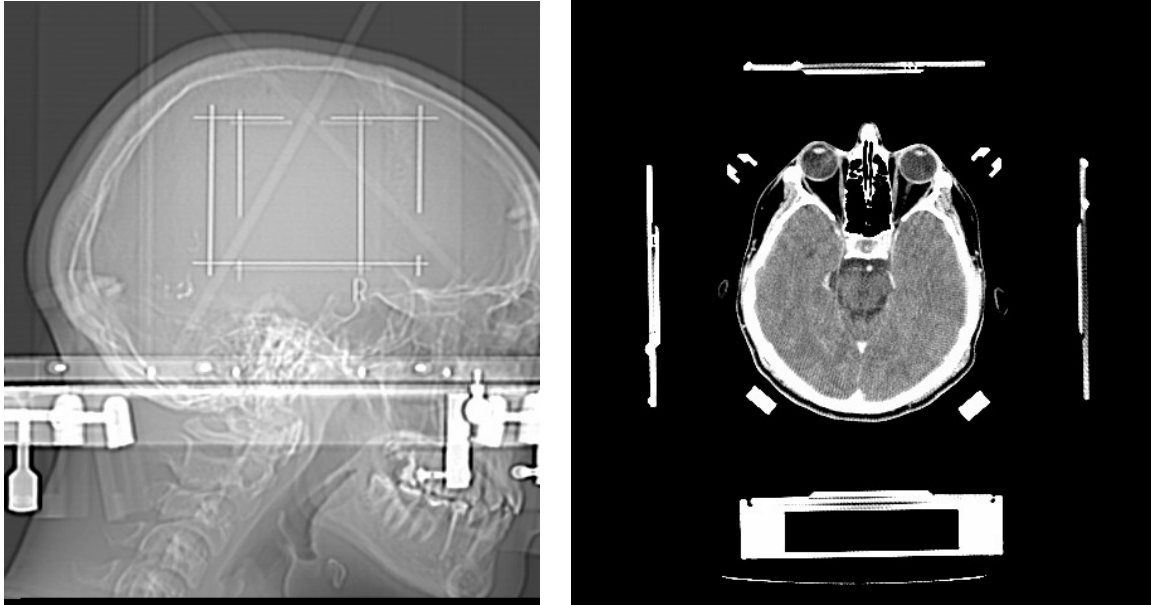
Scout and axial CT image taken for radiation treatment
